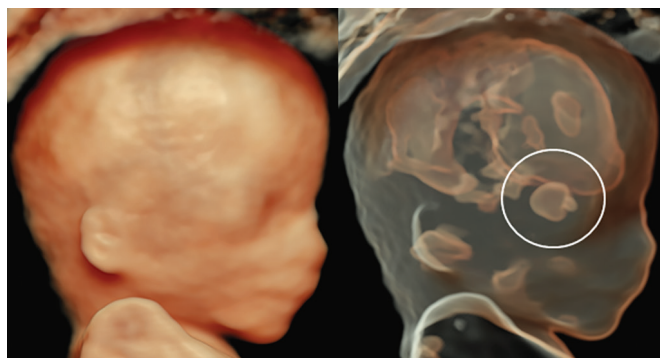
Eye lens and vitreous body at 13 weeks of gestation. Both images are the same volume dataset. Left image is HDlive image and right image is HDlive silhouette image. Silhouette ultrasound demonstrates eye lens and vitreous body (in circle)
